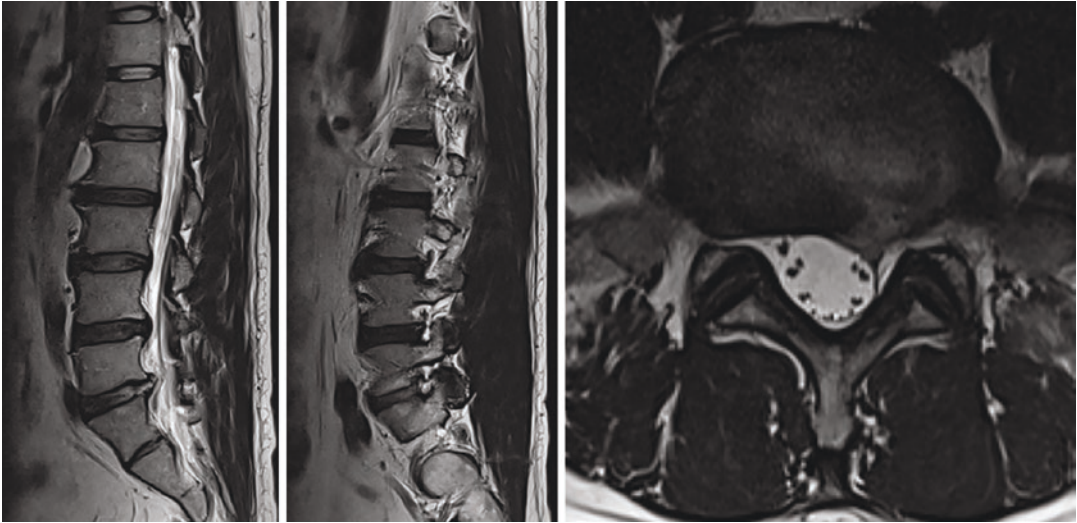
Post-operative MRI images show that both the para-central and extra-foraminal protrusion disc are well removed
